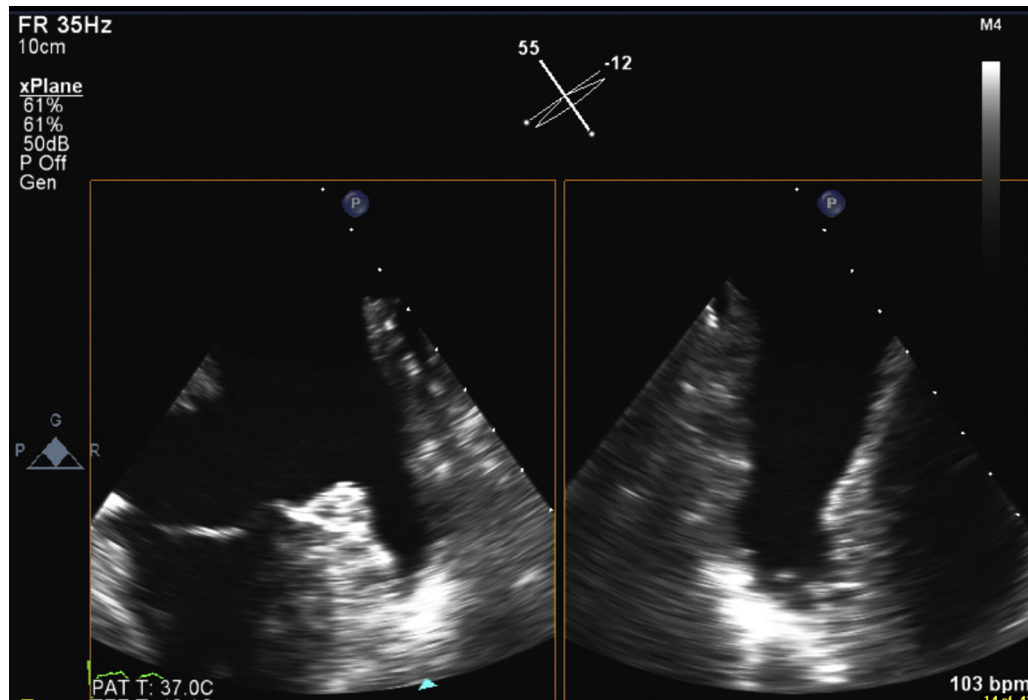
Transesophageal biplane view of the left atrial appendage showing no definite evidence of left atrial appendage thrombus (Supplemental Video 5).
